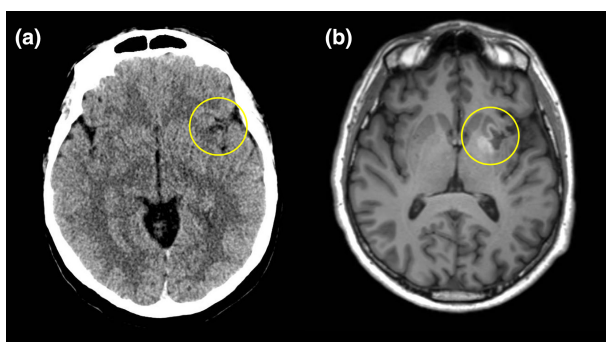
Infarction of the left anterior insula, as indicated by corresponding hypodensity on the 24-h computed tomography scan of the brain (panel a, axial view). A 1-month follow-up magnetic resonance brain scan revealed a residual lesion (panel b, axial view, T1-weighted sequence) featuring a hypointense core (malacic area) surrounded by a hyperintense signal (gliosis).
